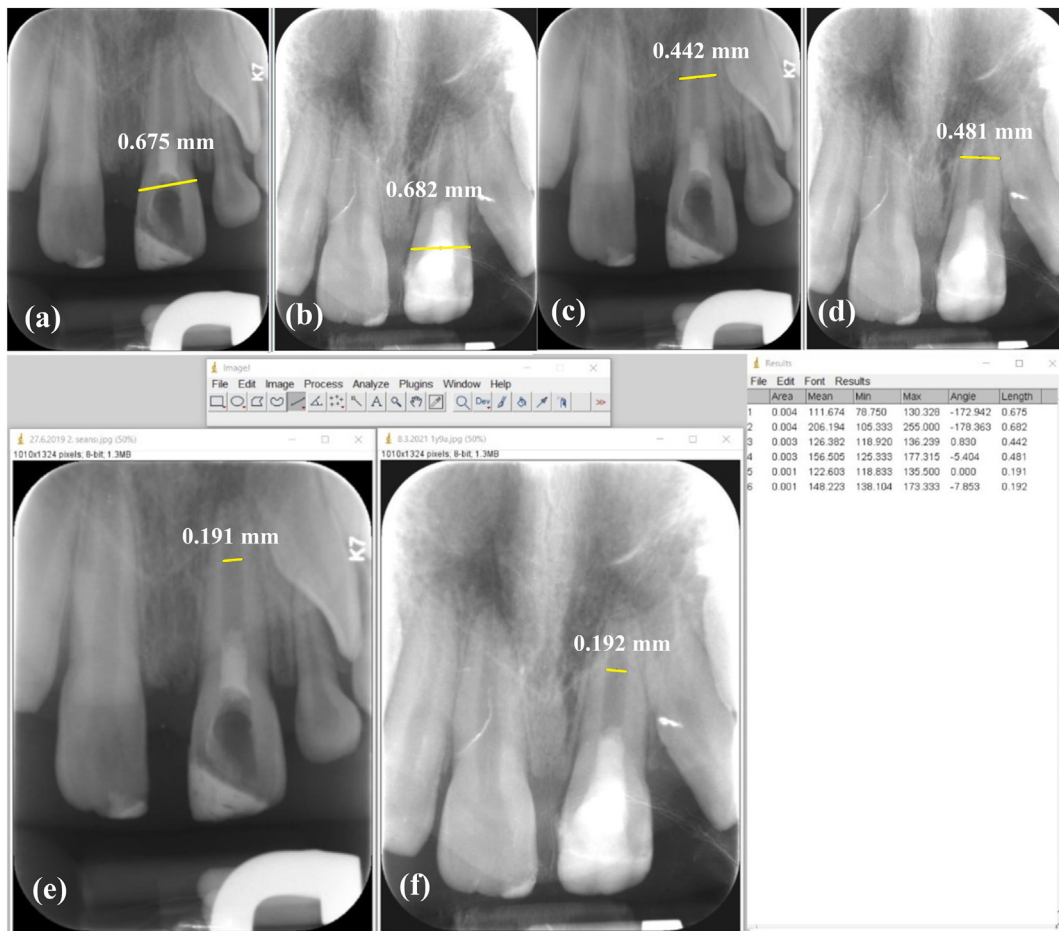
(a,c,e) The first image is the radiograph of the second treatment session (MTA control). (b,d,f) The final image is the final follow-up radiograph of the treatment. Two fixed points in the horizontal plane (mesial and distal CEJ) were selected between the images to measure the dentin thickness in images with different magnification ratios. (a and b) The fixed points in the first and last images were proportioned for the horizontal magnification ratio, and the magnification ratio was found to be $0.675/0.682 = 0.989$. Measurements were made from two-thirds of the root length to measure the dentin thickness. Dentin thickness was measured by subtracting the pulp space from the dentin thickness. (c and e) Dentin thickness in the first image = $0.442 - 0.191 = 0.252$ mm. (d and f) Dentin thickness in the final image = $0.481 - 0.192 = 0.289$ mm. When the final image was converted to the same magnification as the first image, the dentin thickness in the final image was found to be $0.289 \times 0.989 = 0.285821$ mm. The change in dentin thickness between both images was $0.285821 - 0.251 = 0.034821$ mm. When calculated as a percentage according to the first image, $(0.034821/0.251) \times 100 = 13.8729$ was found. As a result, the dentin thickness increased by 13.87% compared to the first image.
